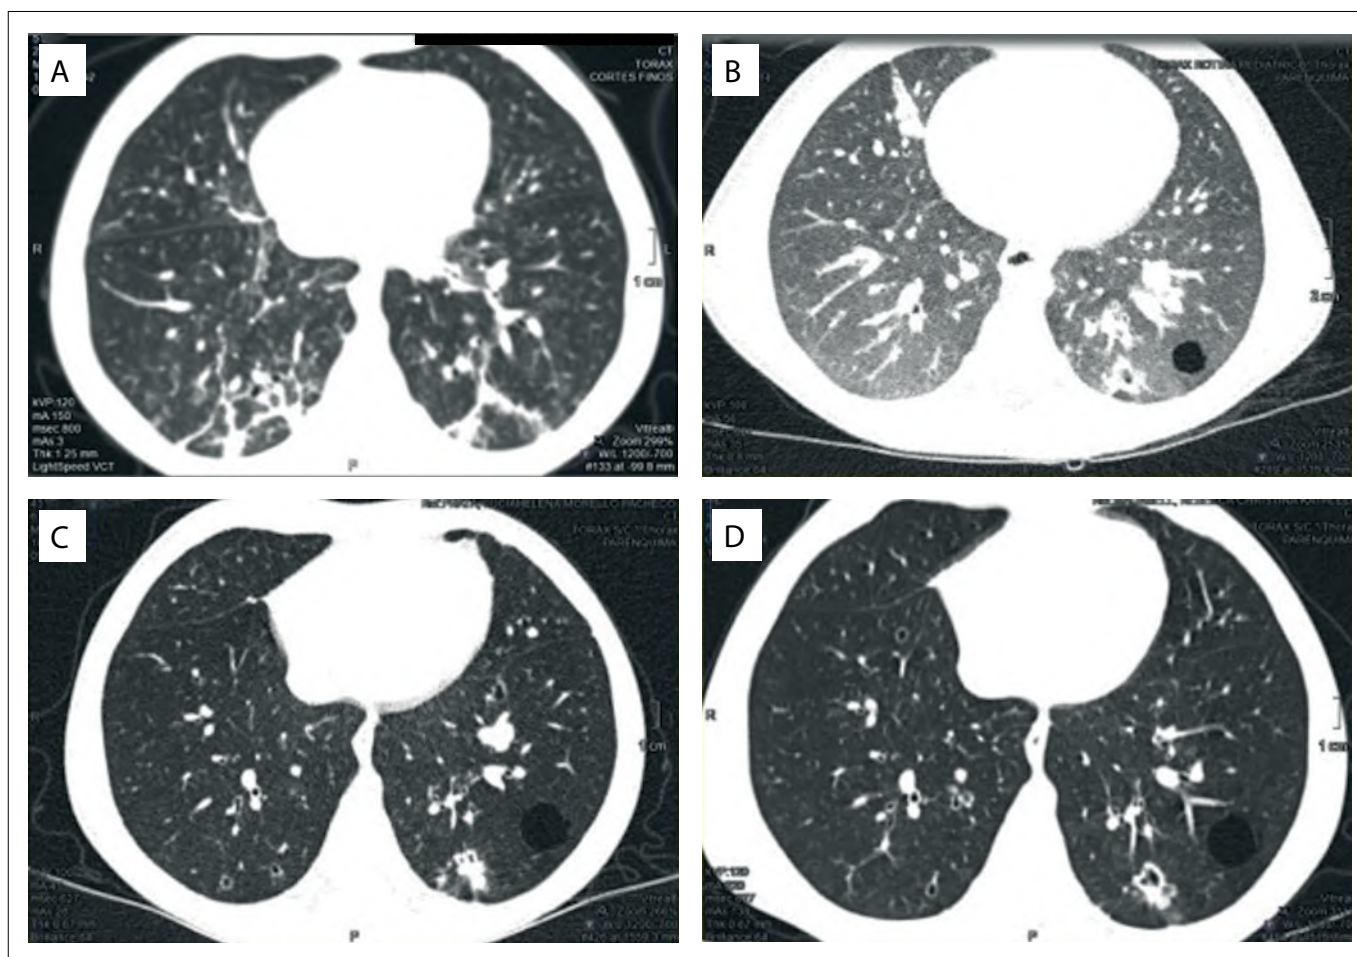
Computed tomography scans in year 3 (A), year 4 (B), year 5 (C) and year 6 (D).
